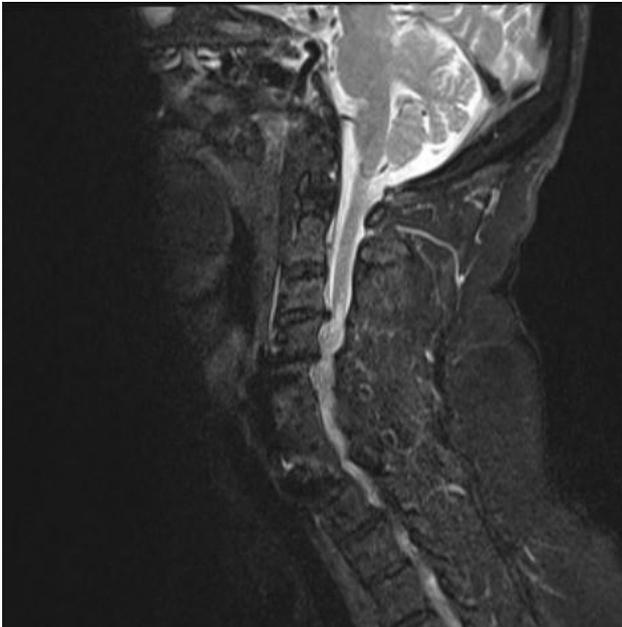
Initial T2-weighted cervical spine MRI
